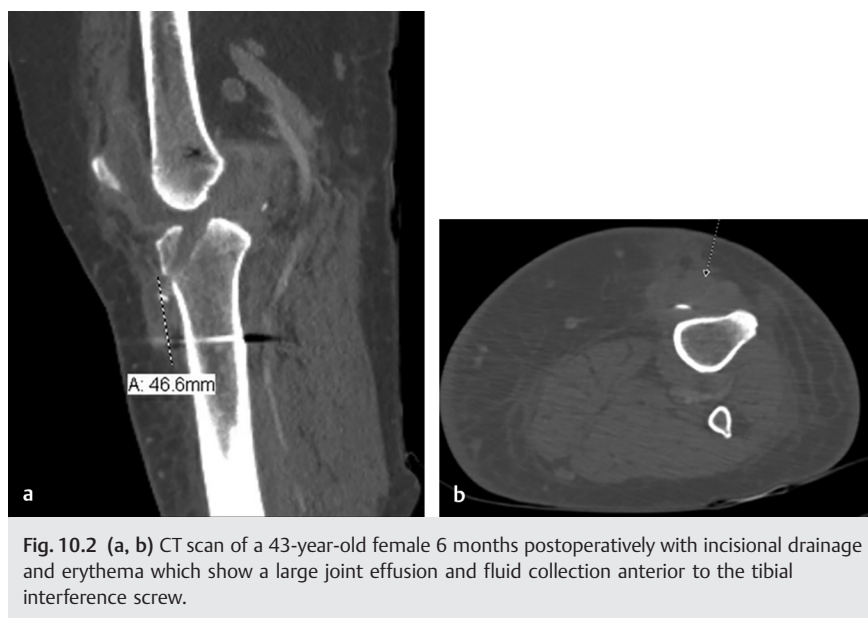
(a, b) CT scan of a 43-year-old female 6 months postoperatively with incisional drainage and erythema which show a large joint effusion and fluid collection anterior to the tibial interference screw.
